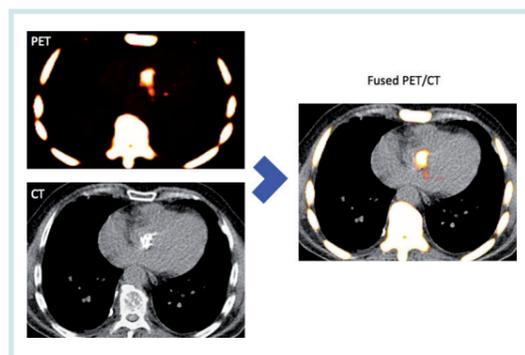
How PET/CT Works
